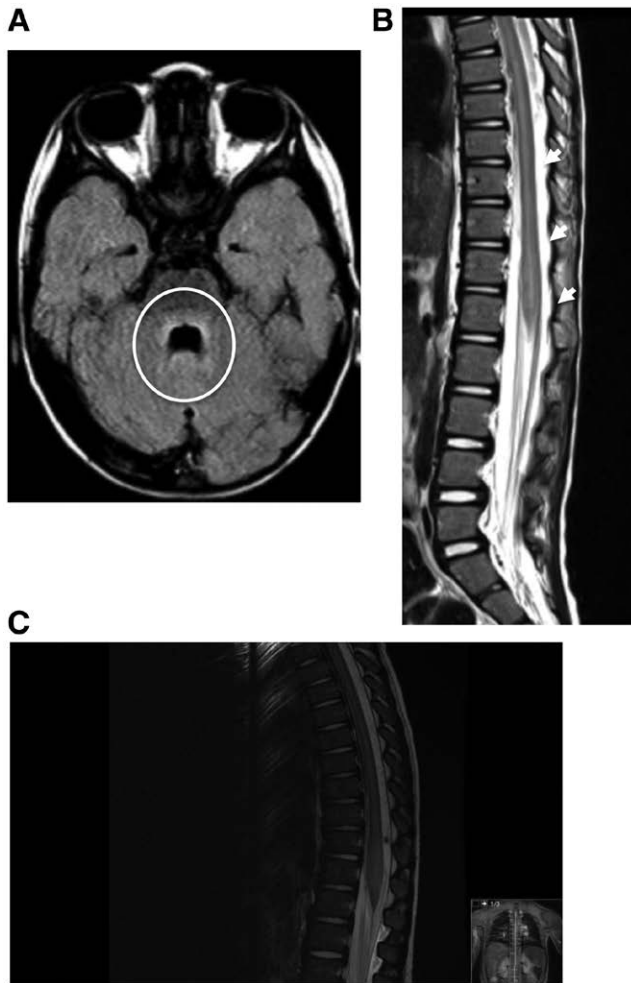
A, Rhomboencephalitis and (B) myelitis in cerebral and spinal magnetic resonance imaging (courtesy of the Neuroradiology Unit, Department of Pediatric Radiology, Vall d'Hebron University Hospital). C, Medullary magnetic resonance imaging showing a long segment of myelitis from C1-CS to the medullary cone.
